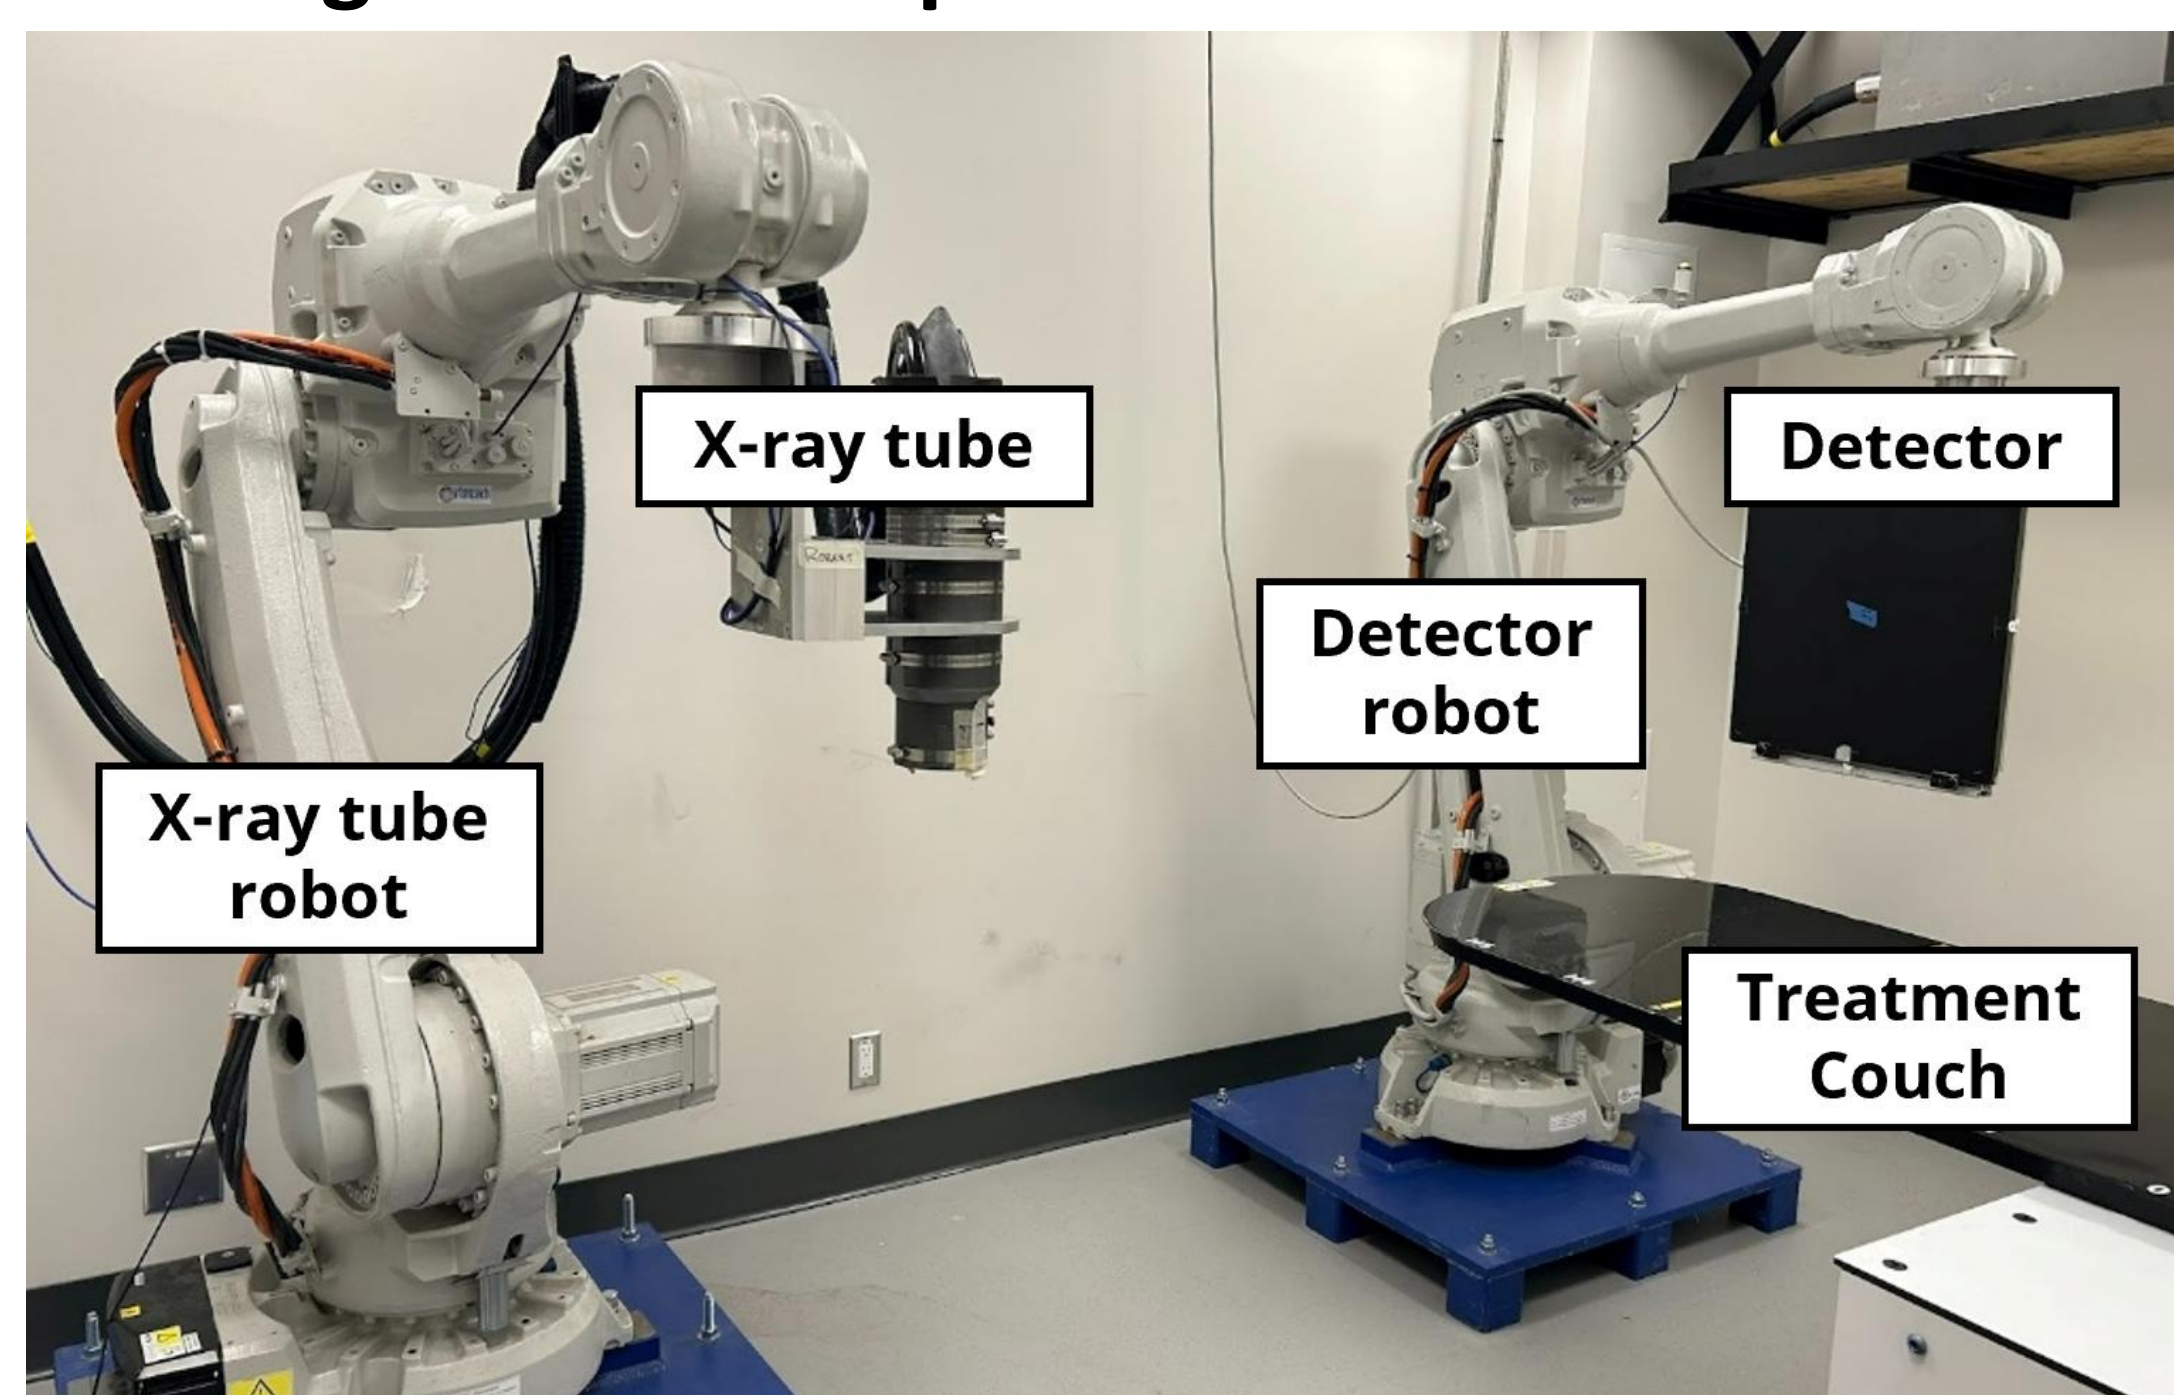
KOALA system, consisting of a 225 kVp x-ray tube and a flat panel detector, mounted on distinct robotic arms (Linden Technologies, USA).
